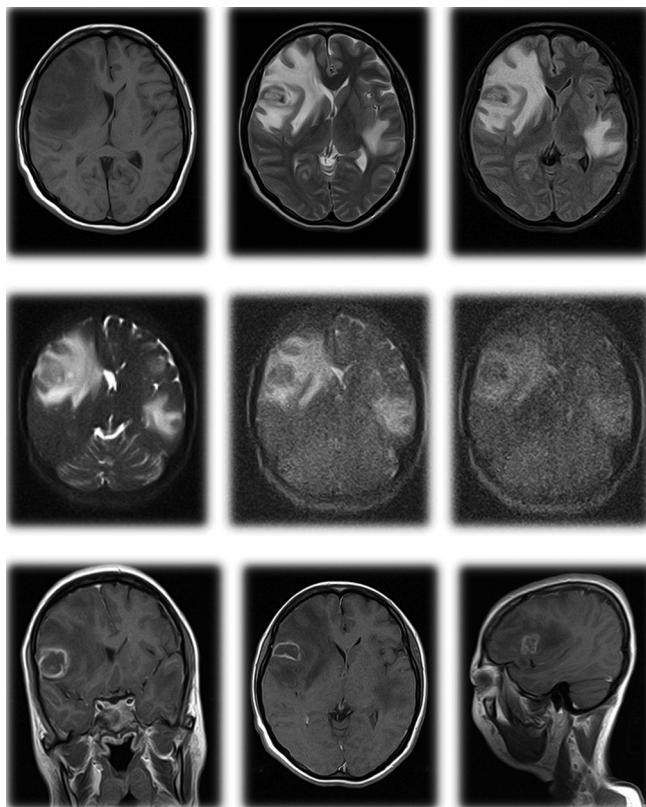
T1, T2, flair, DWI And contrast enhanced images in a case of CNS tuberculoma – multiple rim enhancing lesion in the corticomedullary junction of right frontal lobe and left parietal lobe with mass effect, midline shift and central necrosis.
